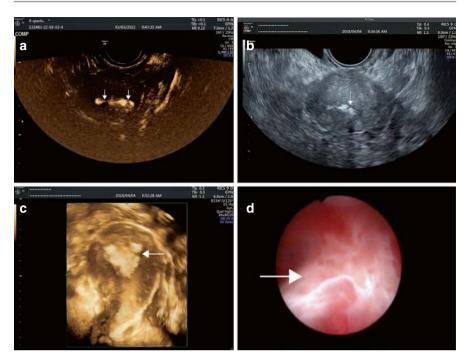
(a) Intrauterine adhesion visualized in contrast mode (arrows indicate the adhesion bands). (b) Intrauterine adhesion visualized on uterine SIS (the arrow indicates the adhesion band). (c) Intrauterine adhesion displayed in the coronal plane on 3D ultrasound (the arrow indicates the adhesion band). (d) Intrauterine adhesion observed under hysteroscopy (the arrow indicates the adhesion band)
